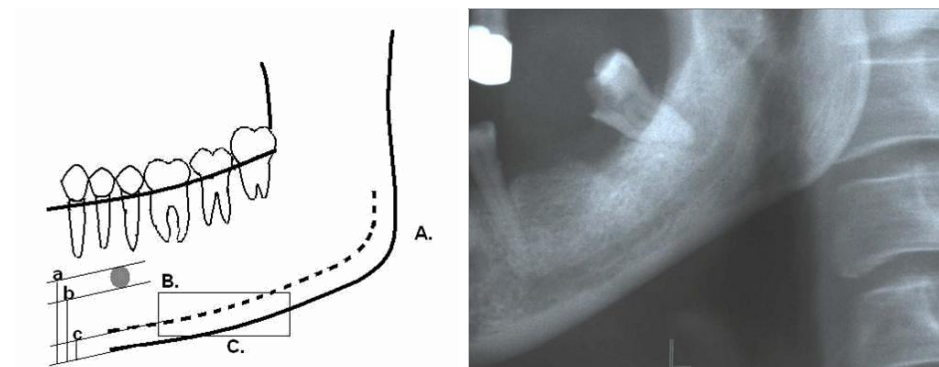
Regions for measuring mandibular bone changes in vivo on panoramic radiographs
